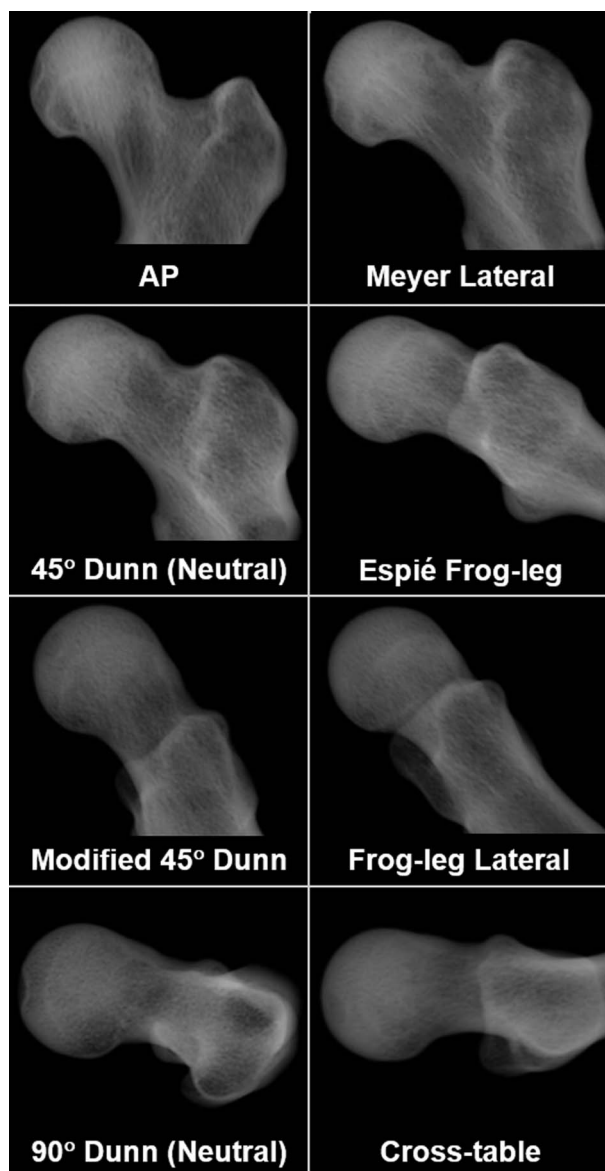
Digitally reconstructed radiographs show the eight views analyzed in this study. The radiographs shown are from a representative patient with cam FAI (26-year-old man). Alpha angle and head-neck offset measurements were obtained from each of the eight views for each femur.
